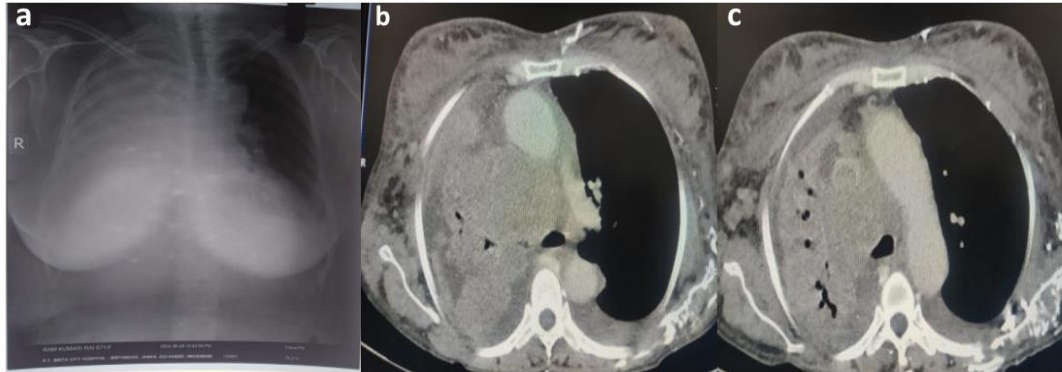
Imaging findings: (a) Chest x-ray with collapsed right lung lobe (b) Right lung soft tissue lesion noted in right hilar region causing narrowing of right primary bronchus with collapsed right lung lobe and air bronchogram. (c) A lesion noted encasing superior venacava with internal hypodense area likely tumor thrombus.
